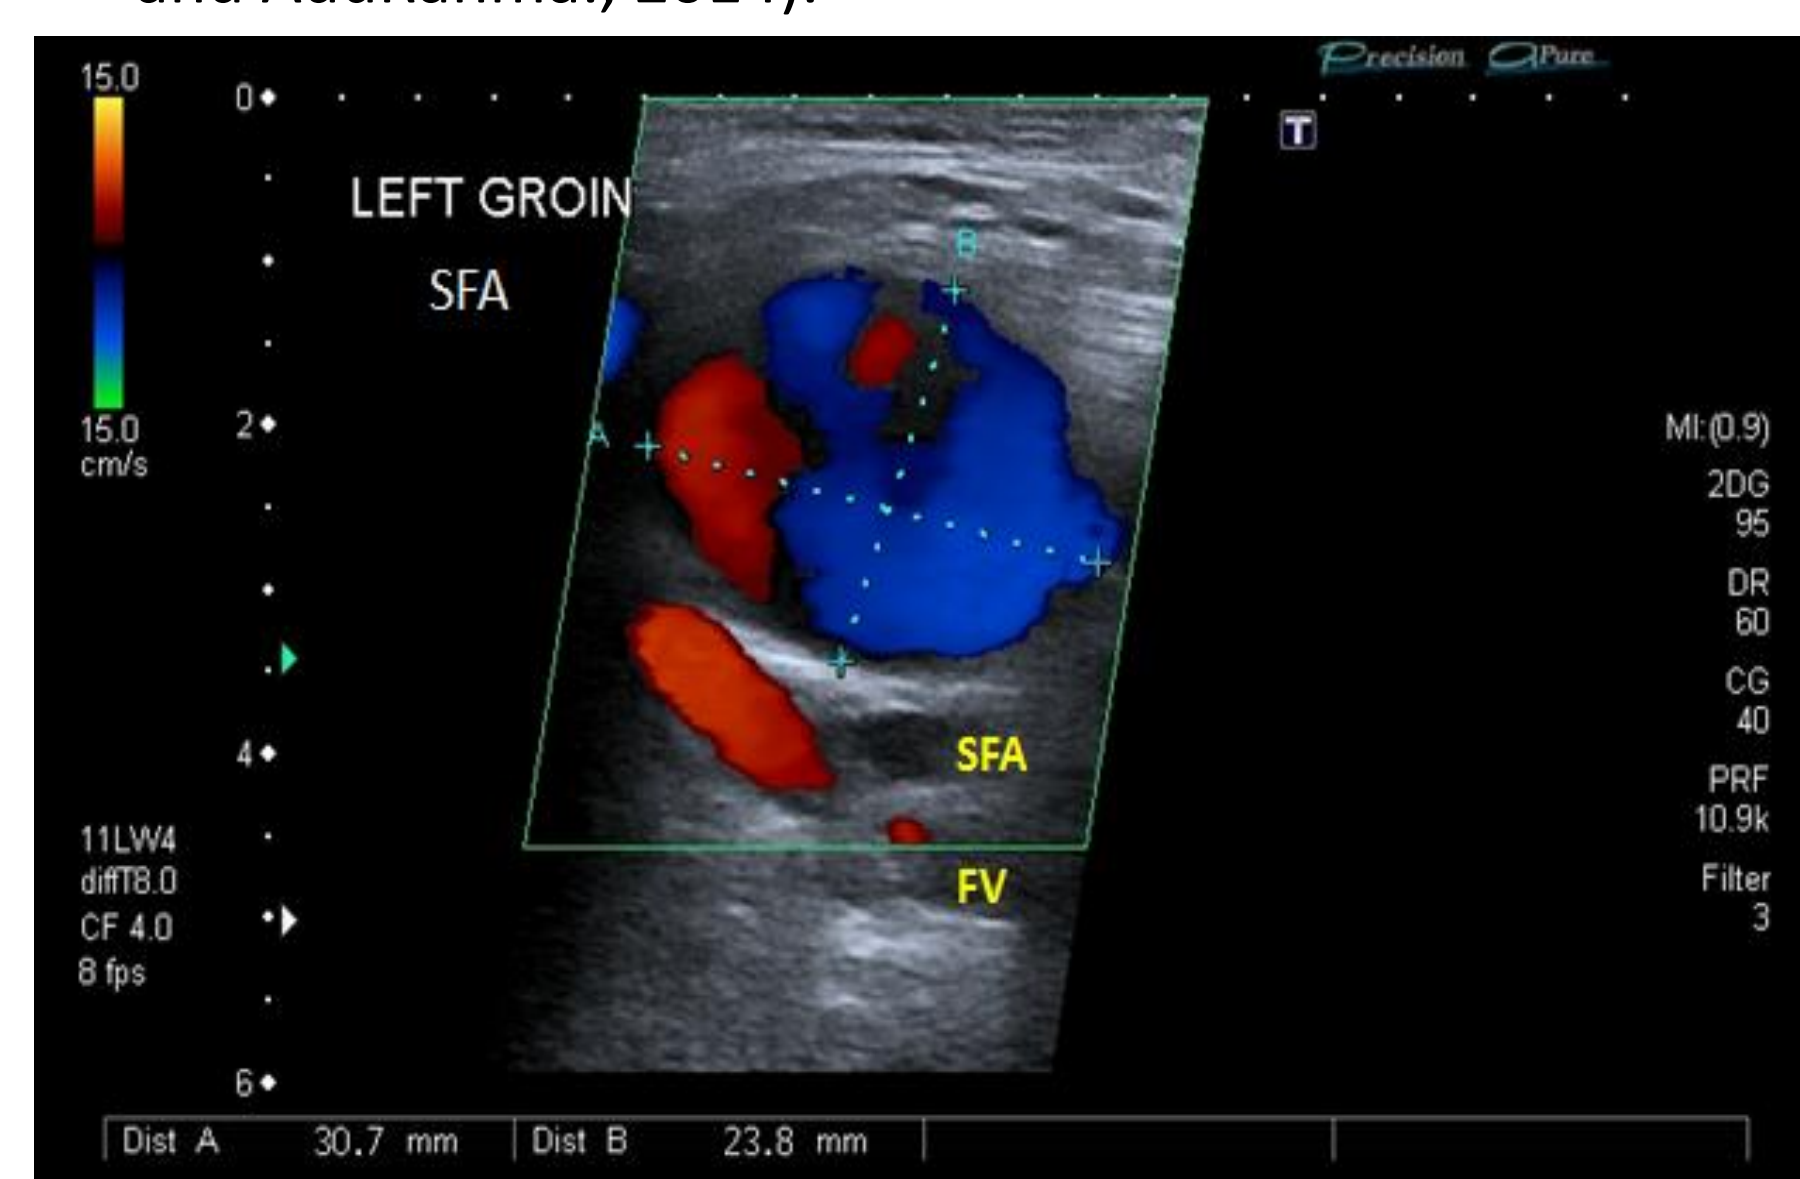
LS colour Doppler image of the PSA, measuring 3.07 x 2.38 cm at the widest point.
